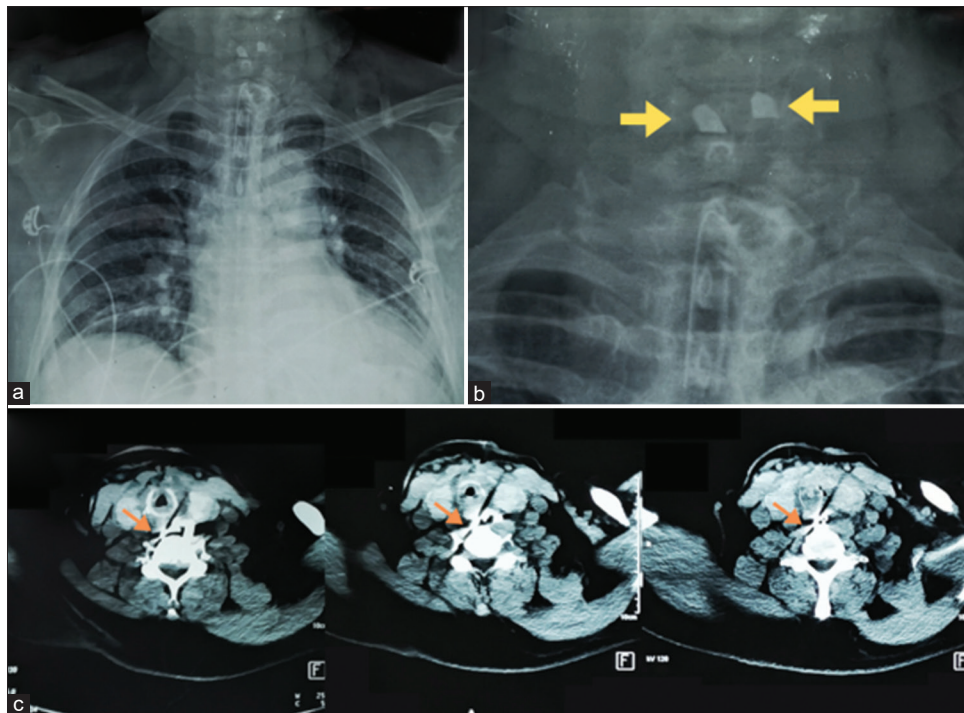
(a) Chest radiograph in anterior-posterior projection, (b) demonstrating two blade fragments in zoomed-in view (yellow arrows). (c) Computed tomography of the neck in axial view showing retained blade fragments (orange arrows)
